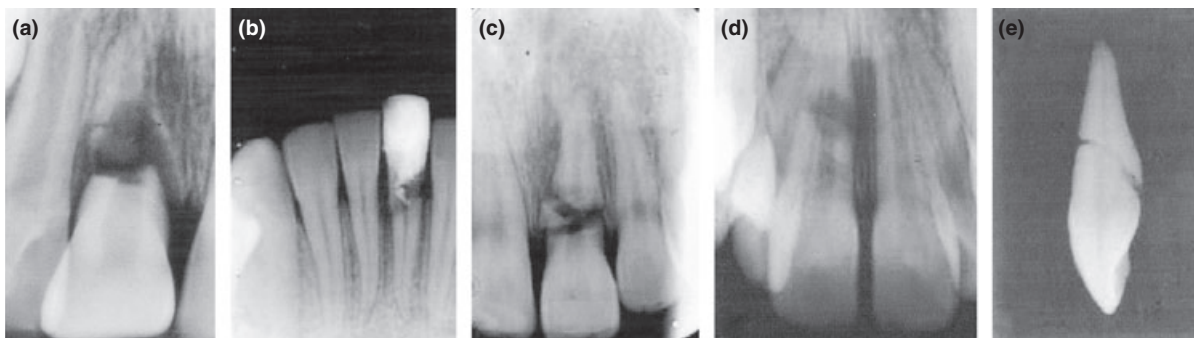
Immediate or delayed extraction of root fractured teeth. (a–c) Two upper and a lower incisor showing complicated cervical fractures 1–3 days after injury, extracted at the first examination. (d) Right central incisor 8 days after injury, with, as it appears, a fracture in middle part of the root. Clinically, there were crowding of teeth, loosening of the coronal fragment and a buccal fistula. (e) Radiograph of the extracted tooth (in d) shows an oblique root fracture.
